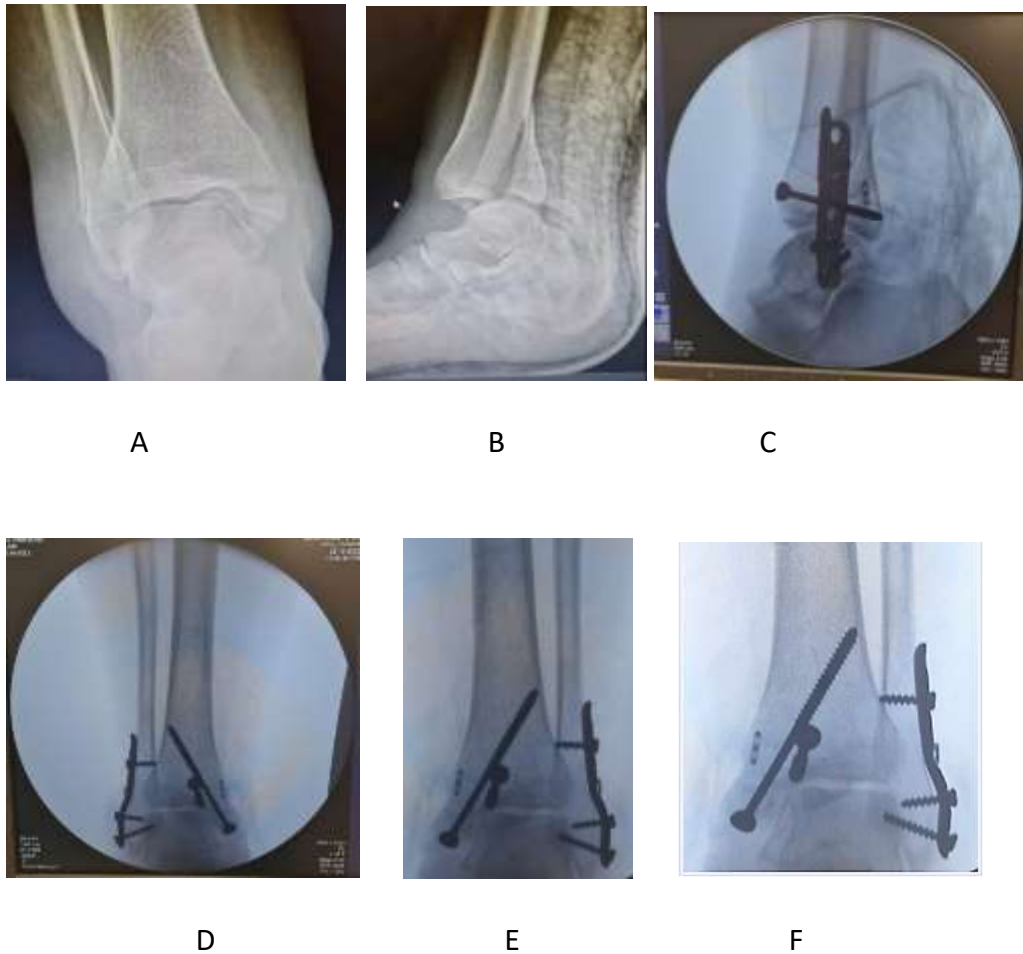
Radiography of a trimalleolar ankle fracture. A, B – Preoperative radiography. C, D – Radiography after surgical treatment with plate and screw fixation of the malleolus and DTFS dynamic fixation system – suture button. E, F – AP x-ray six and twelve months after surgery
